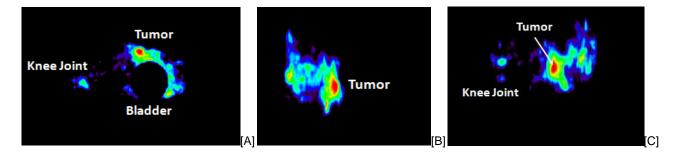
Positron emission tomography image obtained using the easyPET-3D system, observing the activity of <sup>18</sup>F-FDG radiopharmaceutical on 3 different planes: transverse [A]; coronal [B]; sagittal [C]. The bladder was darkened to highlight the tumor and the inflammation site.
